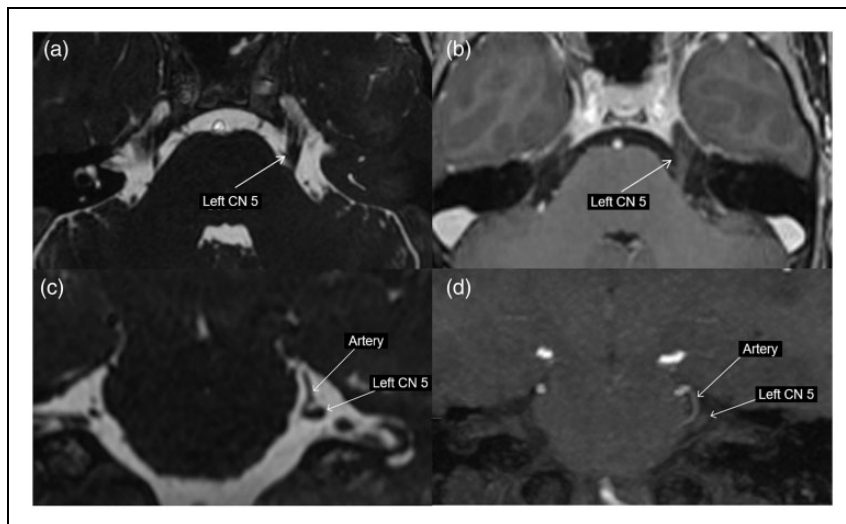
Brain MRI for adolescent female with hemicrania continua and suspected vascular compression: Axial heavy T2-weighted thin cuts (FIESTA) (A) and post-contrast T1-weighted (B) MRI shows asymmetric increased thickness but no enhancement of the cisternal segment of the left cranial nerve 5. (C) Coronal FIESTA and (D) coronal Maximum Intensity Projection reformation of the time of flight MR angiogram show close contact between the enlarged left cranial nerve 5 and a loop of the ipsilateral anterior inferior cerebellar artery.
